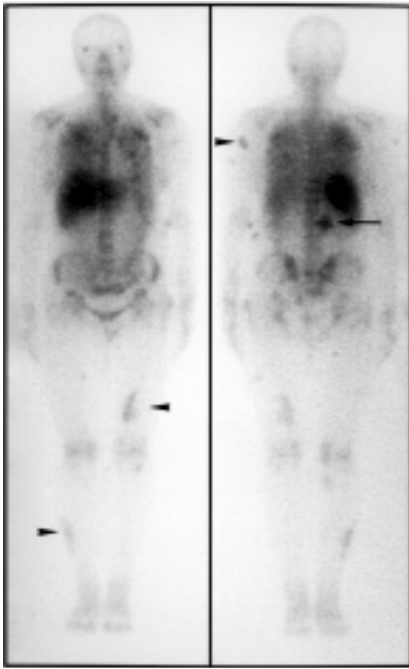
Anterior and posterior whole-body gallium scintigraphy showing multiple focal areas of increased tracer uptake in the tuberculous skin lesions (arrowheads). Bilateral pulmonary and right renal involvement (arrow), are also seen.
